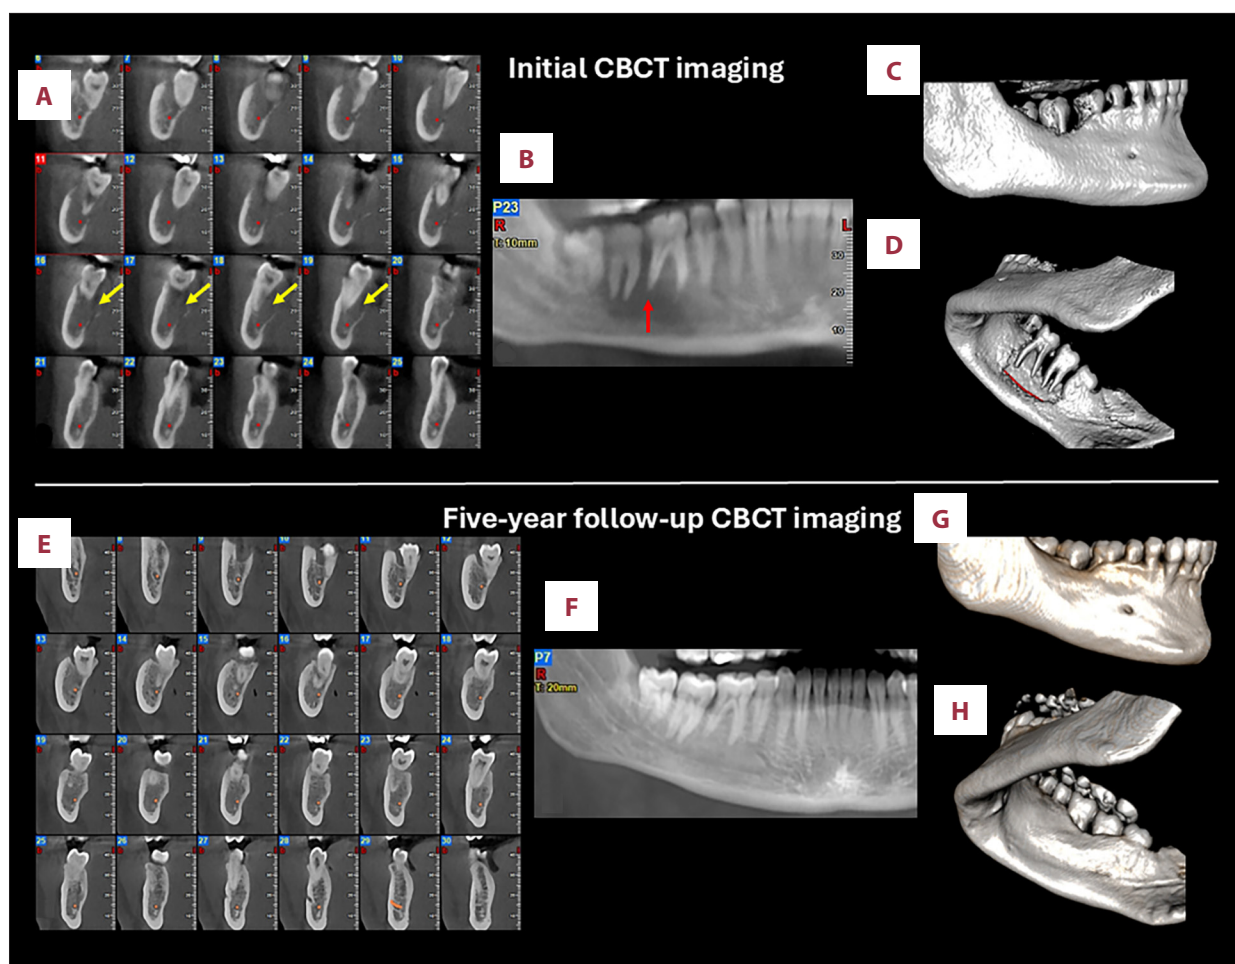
Case 3. (A) Cone-beam computed tomography (CBCT) cross-sectional images showing moth-eaten bone destruction (yellow arrows) and involvement of the mandibular canal (red dots). (B) CBCT panoramic reconstruction demonstrating the floating teeth appearance and spiked-tooth effect (red arrow). (C, D) CBCT three-dimensional (3D) reconstructions (buccal and lingual views) demonstrating lingual cortical perforation and destruction of the supporting alveolar bone of the molars. (E) Five-year follow-up CBCT cross-sectional images showing complete healing of the osteolytic lesion and restoration of the lingual cortical plate. (F) Five-year follow-up CBCT panoramic reconstruction showing complete osseous support of the affected teeth. (G, H) Five-year follow-up CBCT 3D reconstructions showing complete healing of the osteolytic lesion and restoration of the lingual plate.
